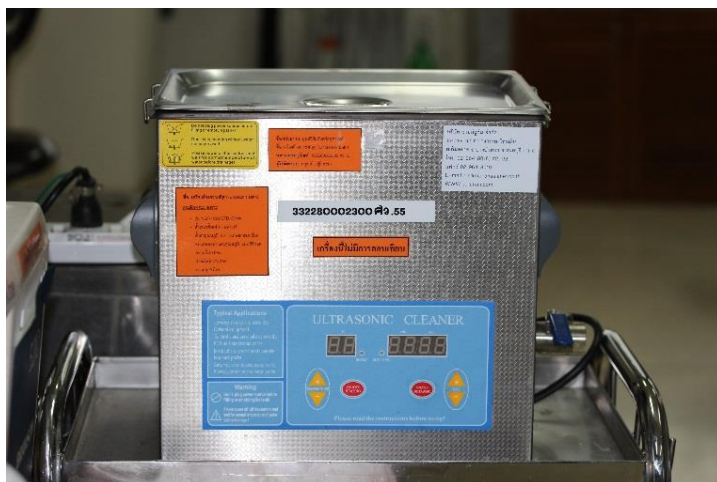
Ultrasonic bath (FZ 40 KHz., VGT-1990 QTD, China)
